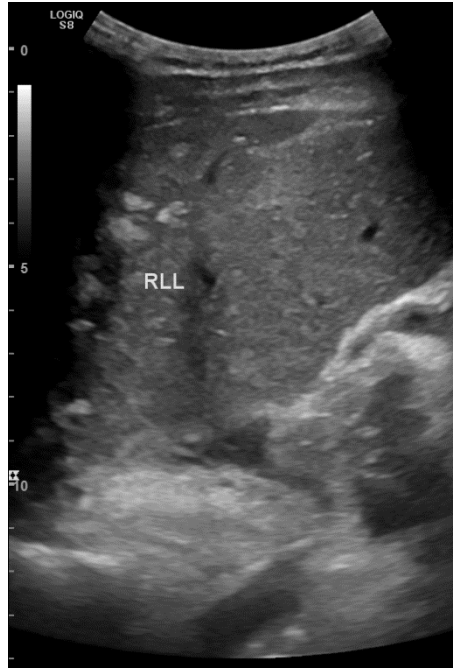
18-year-old male with spontaneous rupture of huge amebic liver abscess. FINDINGS: Five months follow-up after surgery and conservative treatment. Abdominal US showing no evidence of abscess formation in right liver lobe. TECHNIQUE: Abdominal ultrasound using 1-6 MHz curvilinear transducer.
